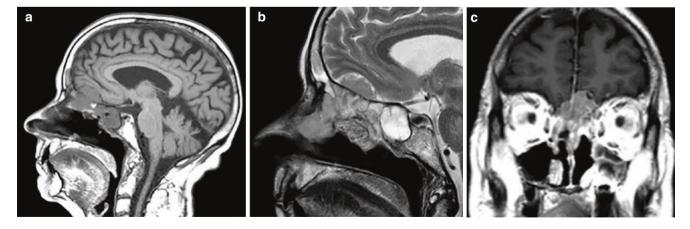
Preoperative magnetic resonance imaging in sagittal (a, b) and coronal (c) planes shows a sinonasal lesion, which occupies the ethmoid cells with extension into the anterior cranial fossa and is closely related to the medial wall of the orbit and the orbital roof on the left side
